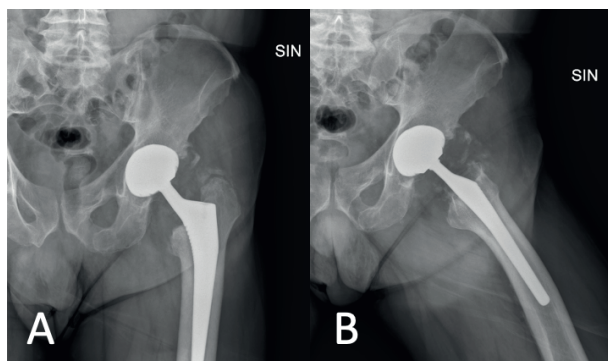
AP (Figure 1A) and Axial (Figure 1B) radiographic views of left hip months after total hip replacement show correct implant positioning and initial heterotopic bone formation.
